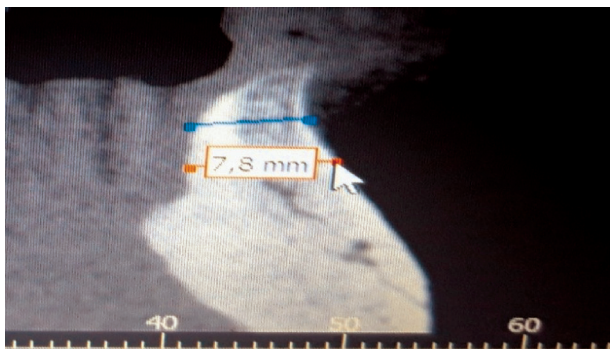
Horizontal dimension (width) of the alveolar ridge in the anterior mandible region (CBCT image).
